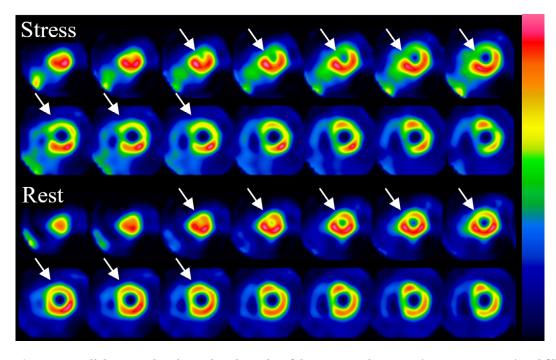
Stress/rest myocardial SPECT showing reduced uptake of the tracer under stress (upper row, arrow) and fill-in at rest (lower row, arrow). These findings indicate a LAD territory ischemia and a subendocardial infarction.
